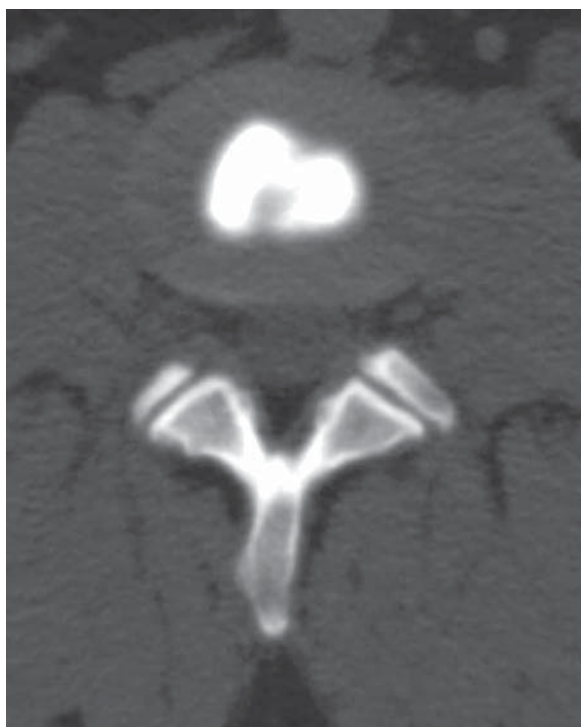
Axial CT following a discogram showing contrast within the central confines of the nucleus pulposus. This is a normal appearing or grade 0 disc.
